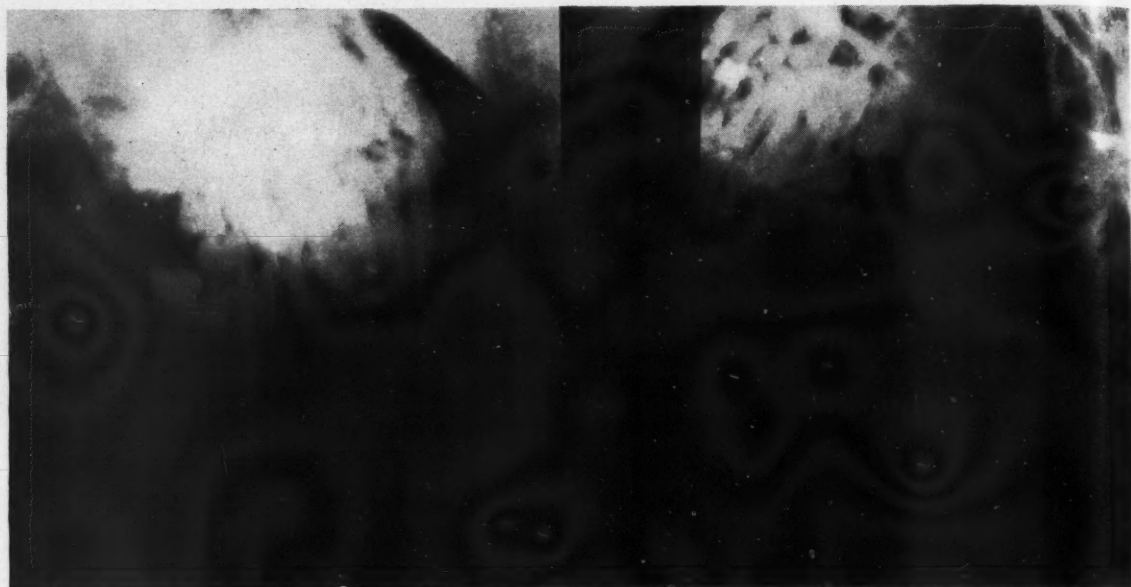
Roentgenograms of patient at age of 21. The right third molar was exposed and it erupted into normal position. The left third molar was not treated and it failed to erupt normally.
